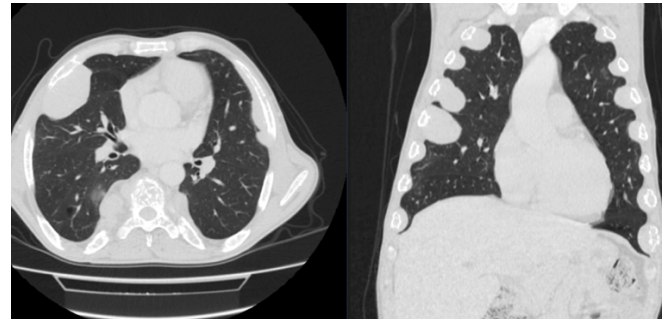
The density of the liver was visualized to be diffusely increased and the spleen was not visualized on CT due to splenectomy.
